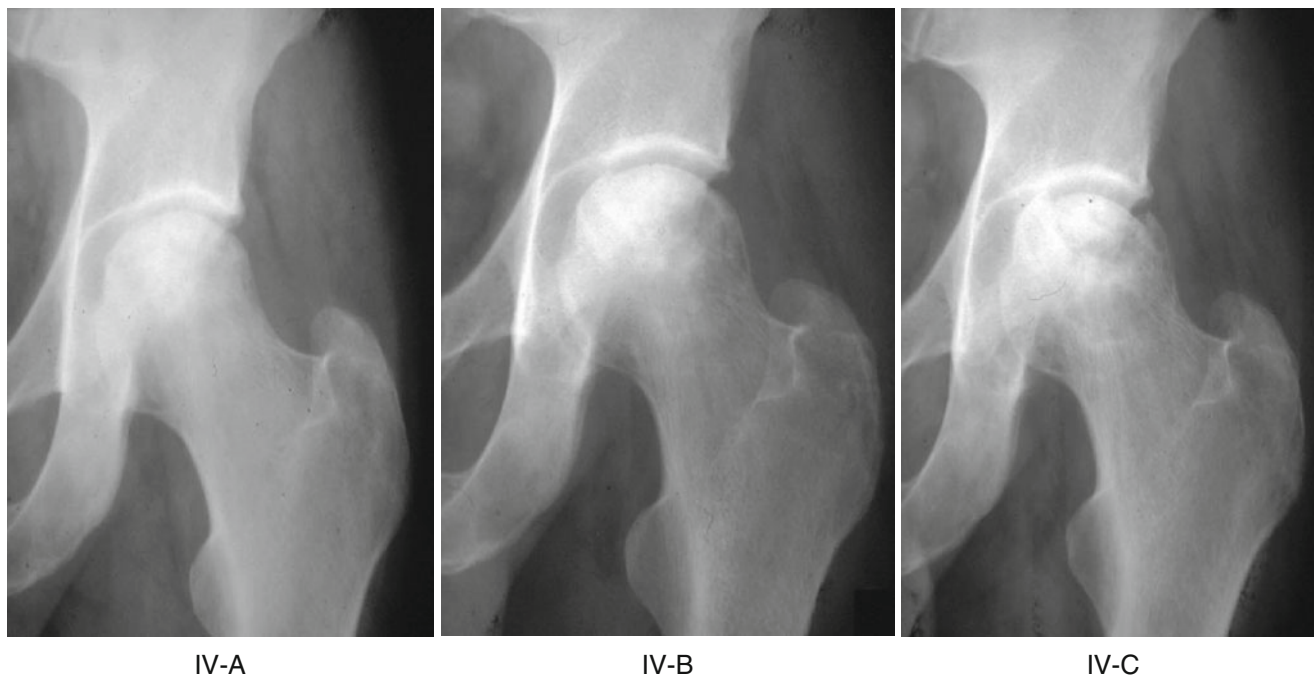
Anteroposterior radiographs of the left hip of a patient with stage IV osteonecrosis. In 4 months the condition progressed from stage IV-A to stage IV-B and eventually to stage IV-C. This obvious
